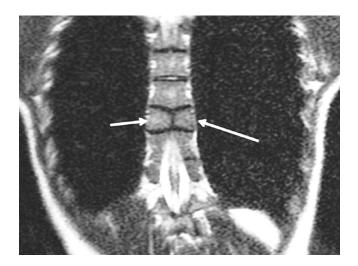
MRI, T2 SSFSE (Single shot fast spin echo) sequences. In this coronal view, there is a failure of fusion of the anterior vertebral arch of the eighth thoracic vertebra, which appears divided into right (short arrow) and left (long arrow) hemisomes.
